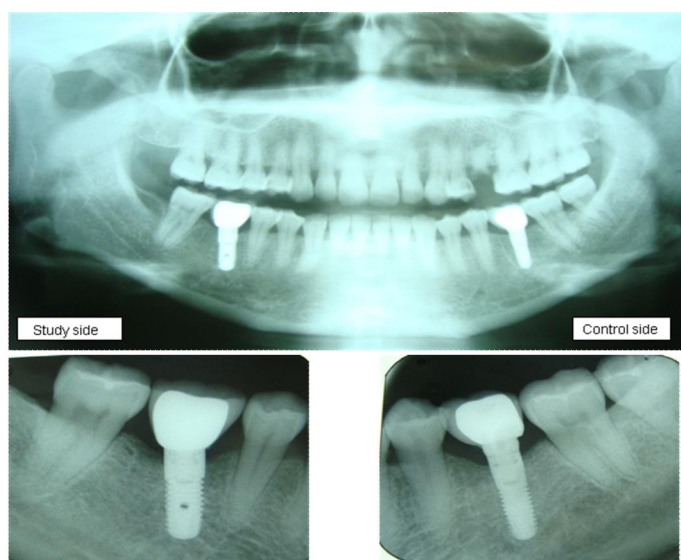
the panoramic view done at insertion of the crowns and the periapical radiographs at 6 months after delivery of the crowns for one case.
